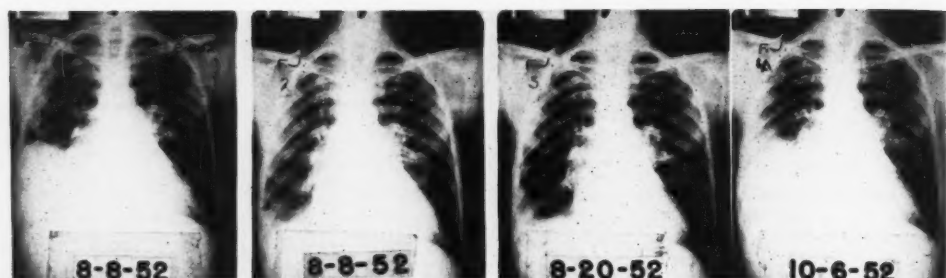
Serial chest roentgenograms on patient F. J., male, age 52. The first and second chest plates were taken on the same day, before and after aspiration.
